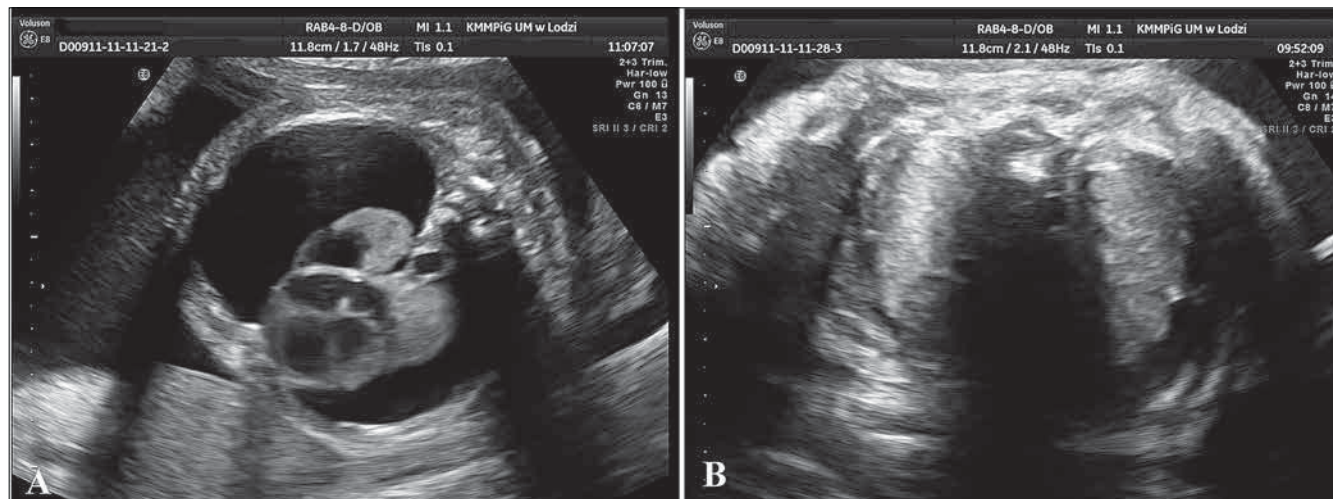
Case I. Ultrasonographic scan of bilateral, hypoechoic fluid in the pleural space at 30 weeks of gestation (A) Expansion of the left lung, lack of fluid in the left pleural cavity and small amounts in the right one at 31 weeks of gestation (B).
